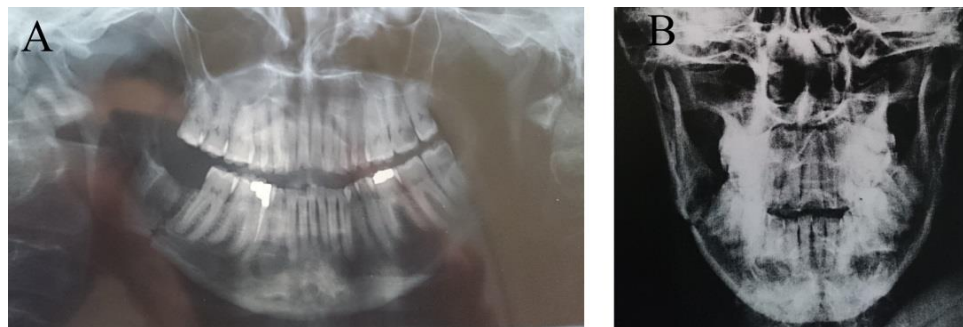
Radiographic images of the patient's mandible immediately after tooth extraction. A- Panoramic view. B- Poster anterior (PA) view of the mandible.
